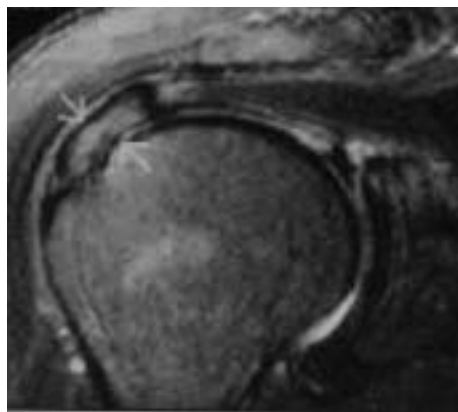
Magnetic resonance image of the shoulder reveals supraspinatus tendinitis (arrow).
